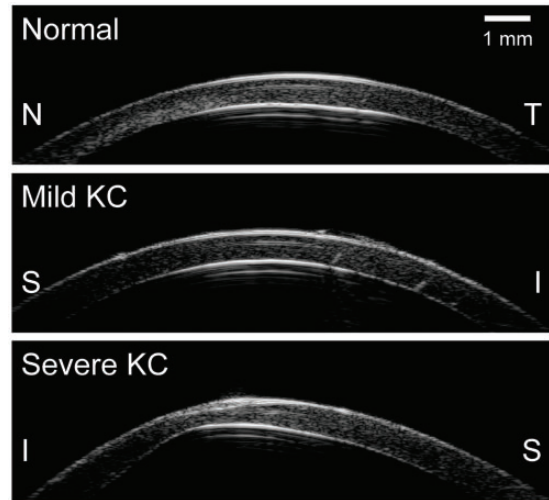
Ultrasound cross-sectional images of a representative normal cornea and both KC corneas (KC1, mild; KC2, severe). S: superior, I: inferior, N: nasal, T: temporal.
